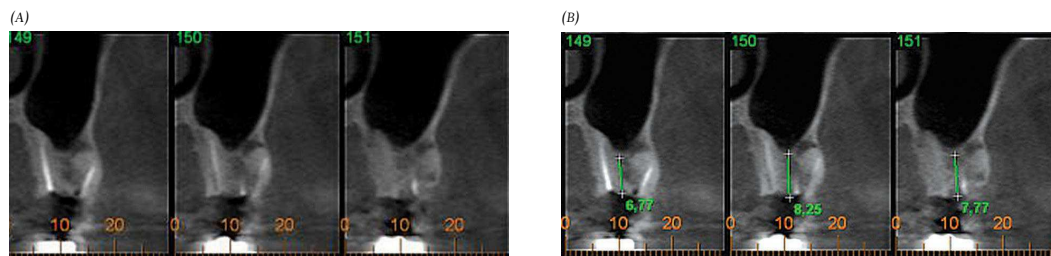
A) Pre-operative cone beam computed tomography. B) Pre-operative cone beam computed tomography with measures that evince remaining bone height.
